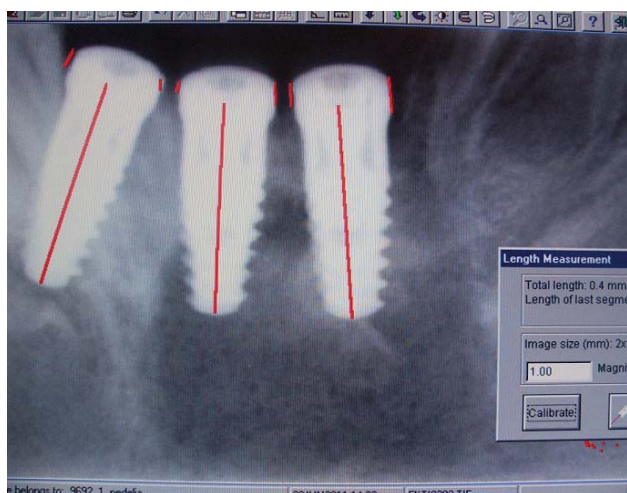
Radiographic analysis – peri-implants bone resorption measuring.
